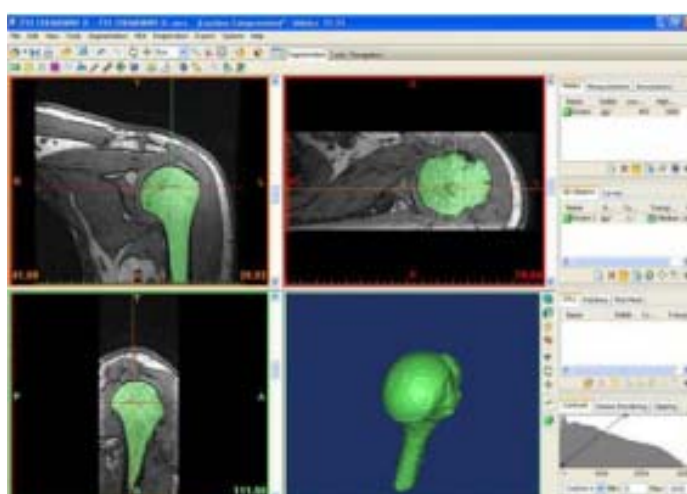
Three views of MRI in Materialize and 3D reconstruction.
